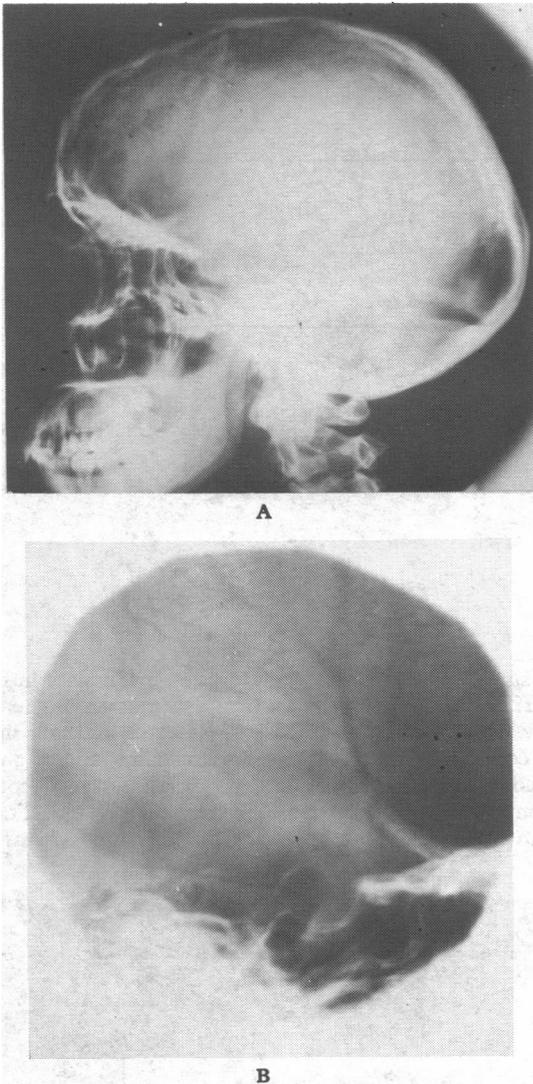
A, Skull x-ray picture showing erosion of posterior clinoid processes with loss of lamina dura of dorsum sellae (21 January 1971). B, Coned film of sella turcica (3 June 1971).
